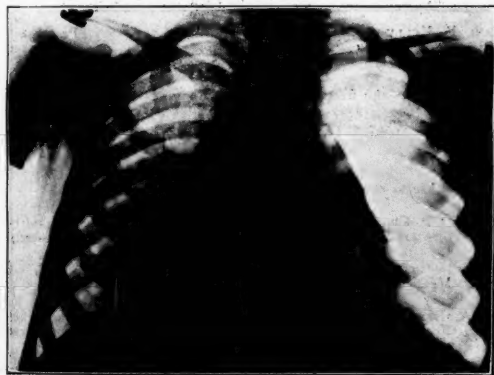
ROENTGENOGRAM TAKEN SIX WEEKS LATER SHOWING PARTIAL RE-EXPANSION OF THE LUNG.
